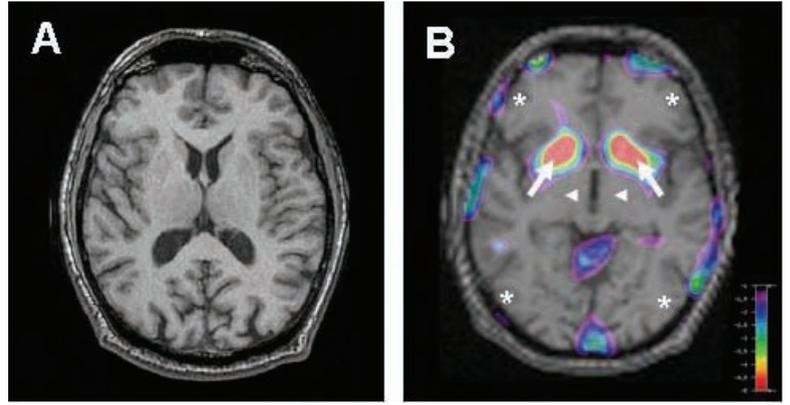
MRI and FDG-PET
